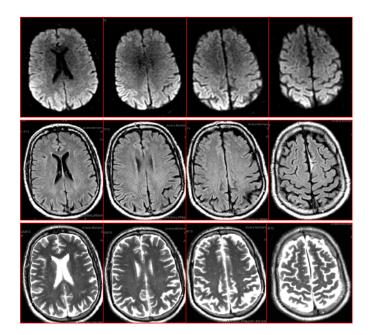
MRI from case 2, obtained 3 weeks after symptom onset. The DWI (upper row in panels A and B) is superior in showing early changes in the cerebral cortex compared to FLAIR (middle row), and T2WI (lower row) sequences.
